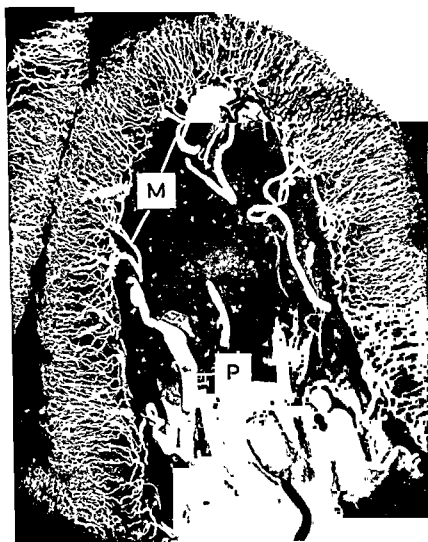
Radiograph of vessels in fold of mucosa from anterior wall of body of stomach P = Submucous plexus. M = Mucosal arteries. ($\times 16$)
